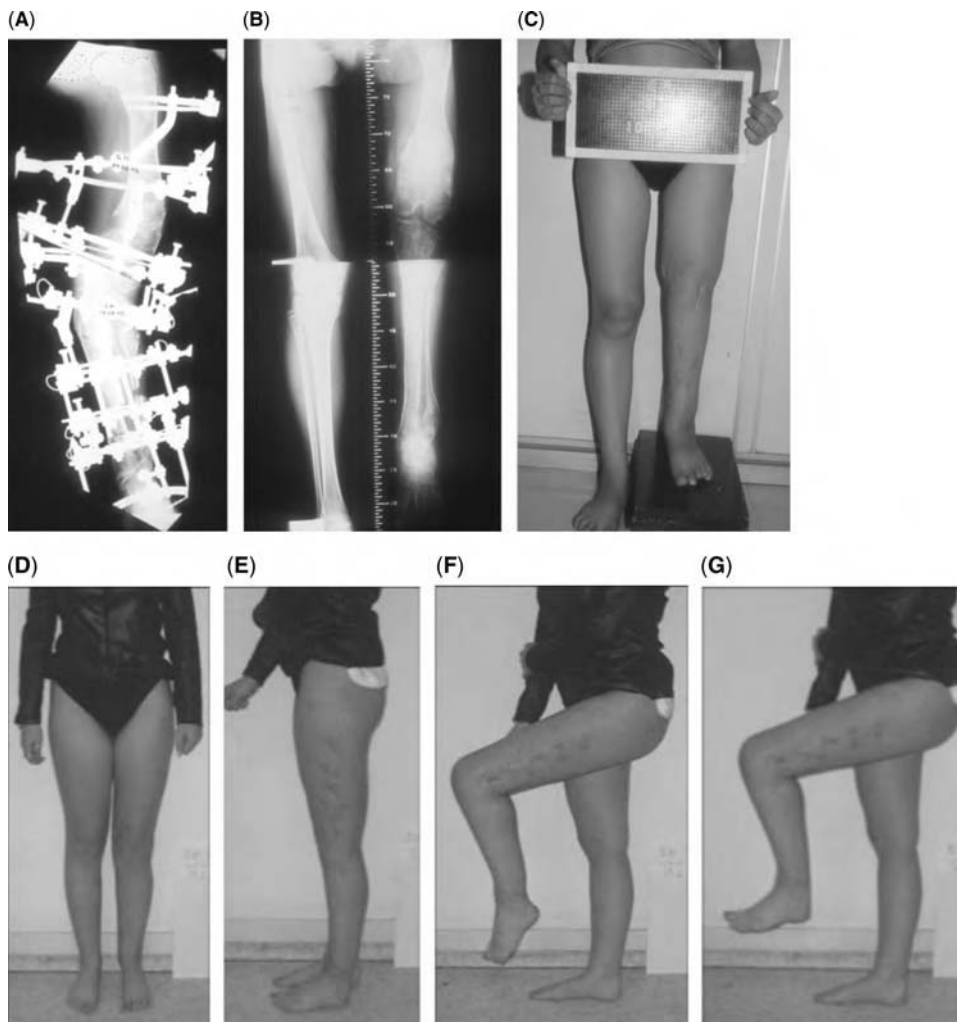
(A) Plain radiograph showing the Ilizarov device in the lower limb (at the beginning of deformity correction). (B) Radiograph showing the correction of deformities (and the partial correction of the leg length discrepancy). Bone neoformation is seen within the chondromas. (C) Photograph of the patient obtained after the first stage of the treatment. The axis of the left limb is fully corrected and discrepancy is partially corrected. (D), (E), (F), (G) The final result of elongation.
